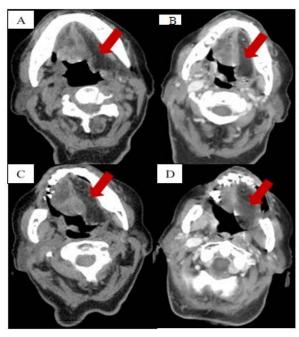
Contrast CT scan of the head, axial view (A, B, C, D), reveals fat-containing lesion in the left half of the tongue (arrows), defined as an area of low attenuation.
